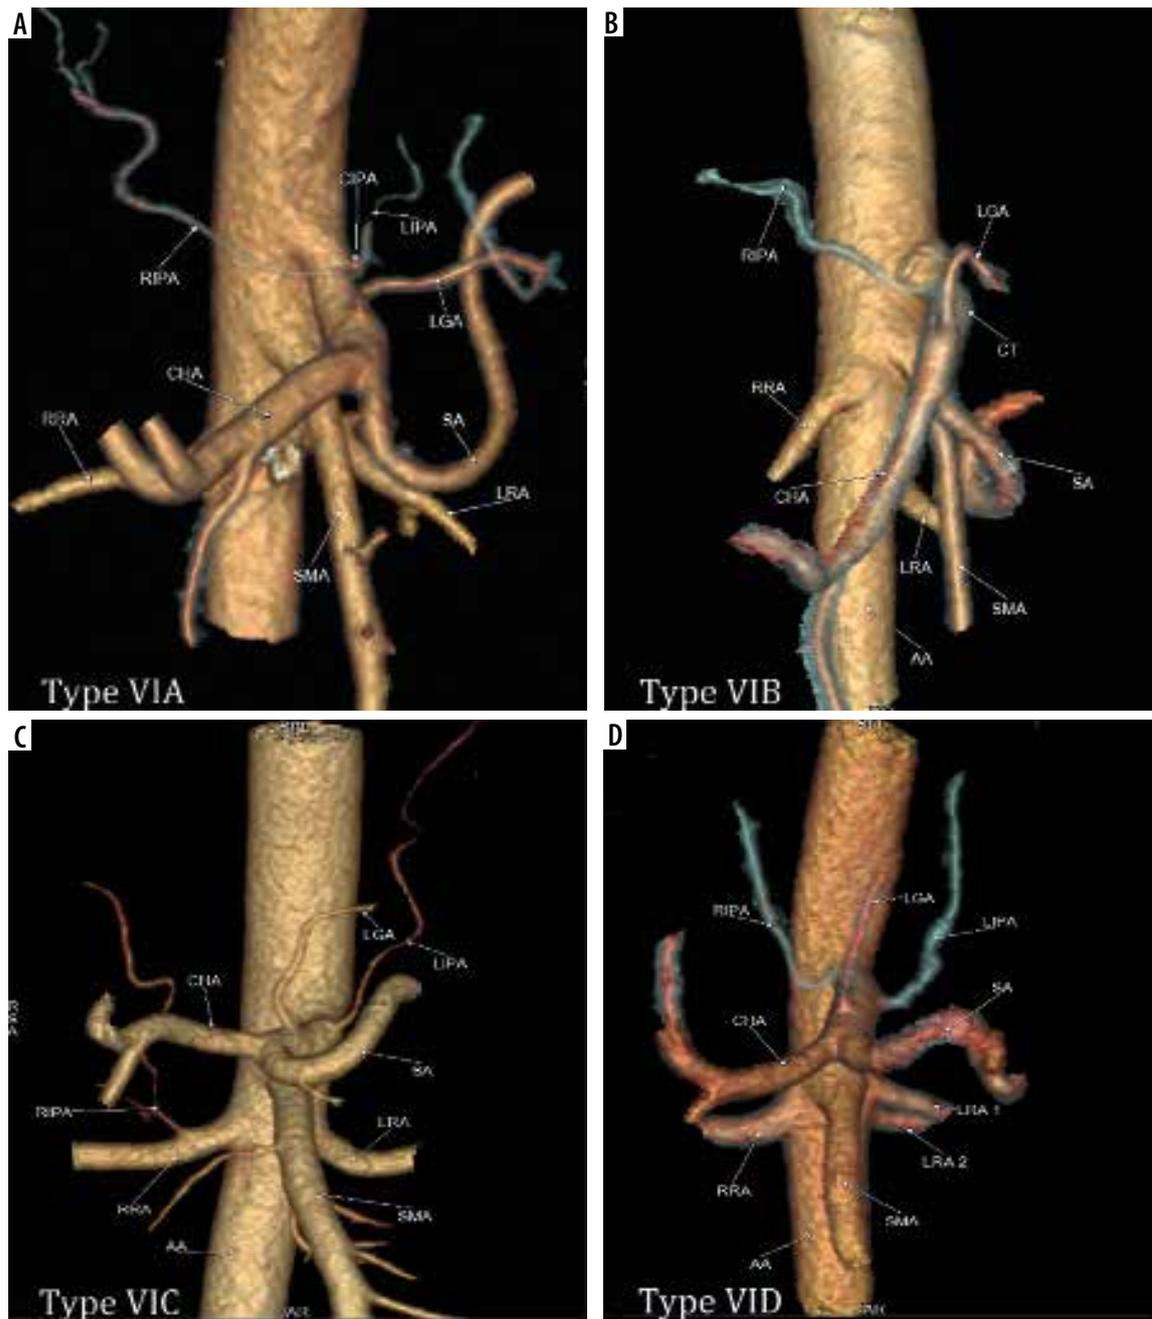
Computed tomography angiography images showing: A) common inferior phrenic artery (CIPA) from celiac artery (CA) (Type VIA), B) right inferior phrenic artery (RIPA) from CA (Type VIB), C) left inferior phrenic artery (LIPA) from CA (Type VIC), and D) bilateral IPA from CA (Type VID)
